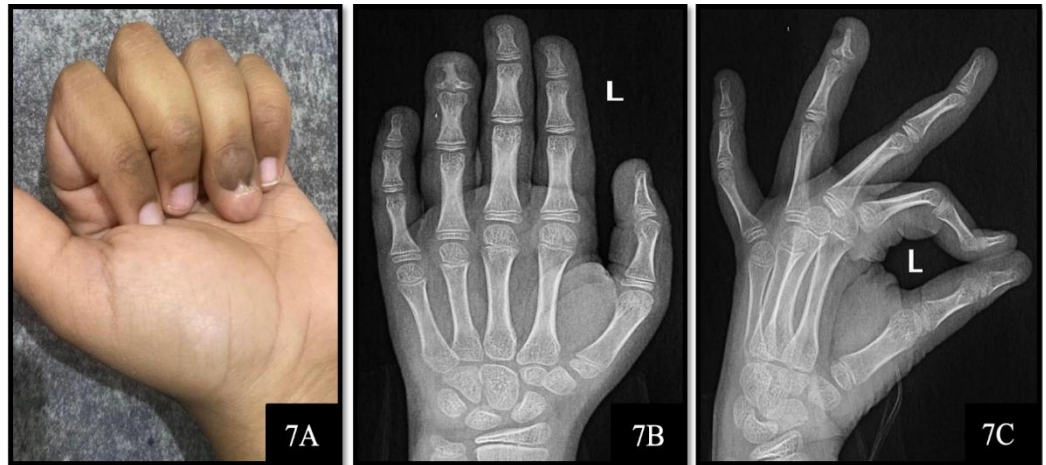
(A-C): (A) Clinical photograph of the patient's hand three years after the surgery. (B,C) AP and lateral radiograph of the left hand three years after surgery, showing no evidence of recurrence.
